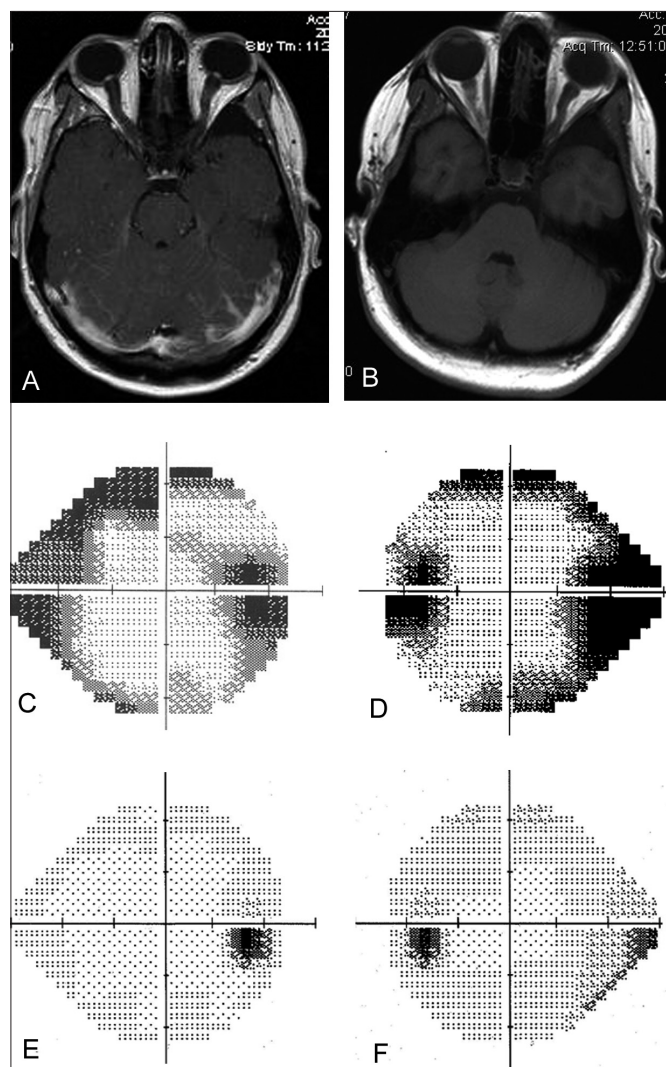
(A) MRI T1-weighted image showing papilledema (bilaterally) with dilated optic nerve sheaths at presentation. (B) Resolved papilledema after rituximab treatment. (C, D) Humphrey visual field (HVF) 24-2 of right and left eye showing enlarged blind spot and constricted visual fields at presentation. (E, F) HVF 24-2 of right and left eye at 9 months showing improved visual fields after treatment with rituximab.
